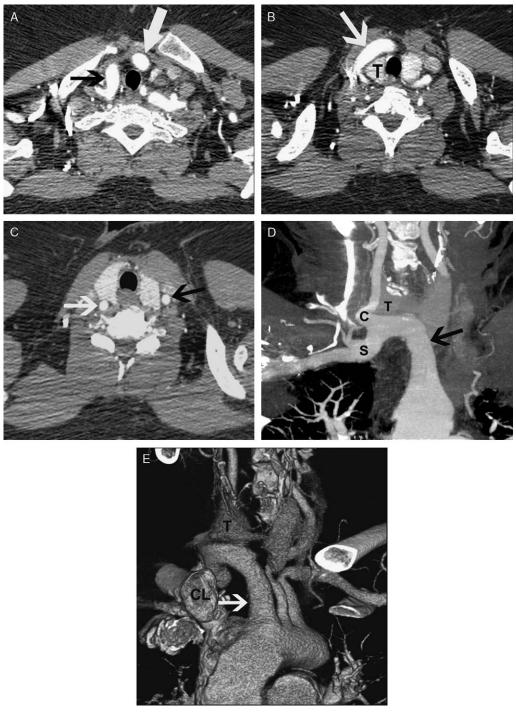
A 66-year-old woman who presented with a pulsatile mass in the neck. A, Axial image from CT scan at the level of the first thoracic vertebral body shows the right brachiocephalic artery (white arrow) just anterior to the trachea. The proximal portion of the right subclavian artery (black arrow) is also seen at this level. B, Axial image at a slightly superior level shows the right brachiocephalic artery (arrow) crossing anterior to the right lobe of the thyroid gland (T). C, Axial image at a more cranial level shows that the right common artery (white arrow) is posterior to the thyroid gland. Note the left common carotid artery (black arrow) in its normal location lateral to the thyroid. D, Coronal maximum intensity projection image demonstrates the right brachiocephalic artery (arrow) ascending to the level of the thyroid gland (T) before branching into the common carotid artery (C) and subclavian artery (S). E, Volume-rendered image from a shallow left anterior oblique perspective depicts the course of the right brachiocephalic artery (arrow) from its origin off the aortic arch to the level of the right lobe of the thyroid gland (T). Note that the right brachiocephalic artery rises well above the medial end of the right clavicle (CL). Although the trachea is not visualized, its position can be inferred from the location of the thyroid gland. The proximal portions of the left common carotid and left subclavian arteries are also shown.
